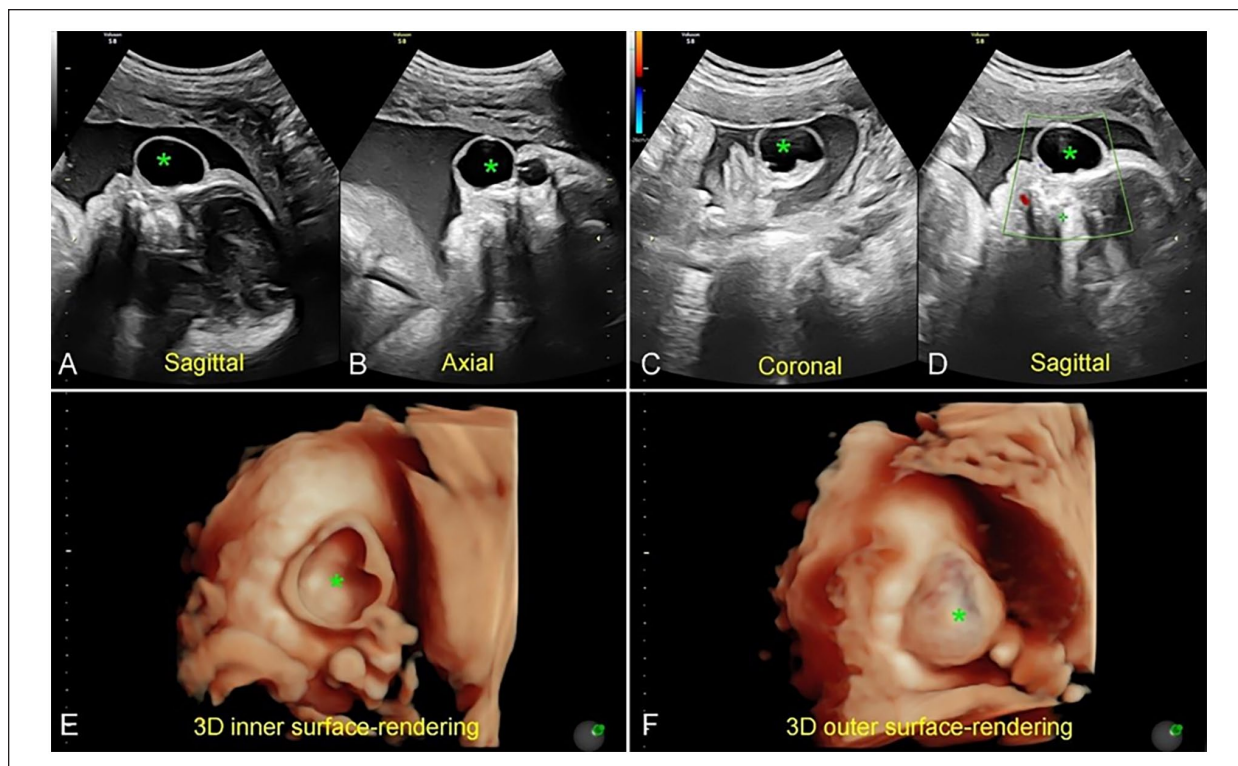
The ultrasound images (A-C), Doppler image (D), and 3D images (E and F) at 30 weeks 2 days reveal a cystic structure between the nose and the right eye.
